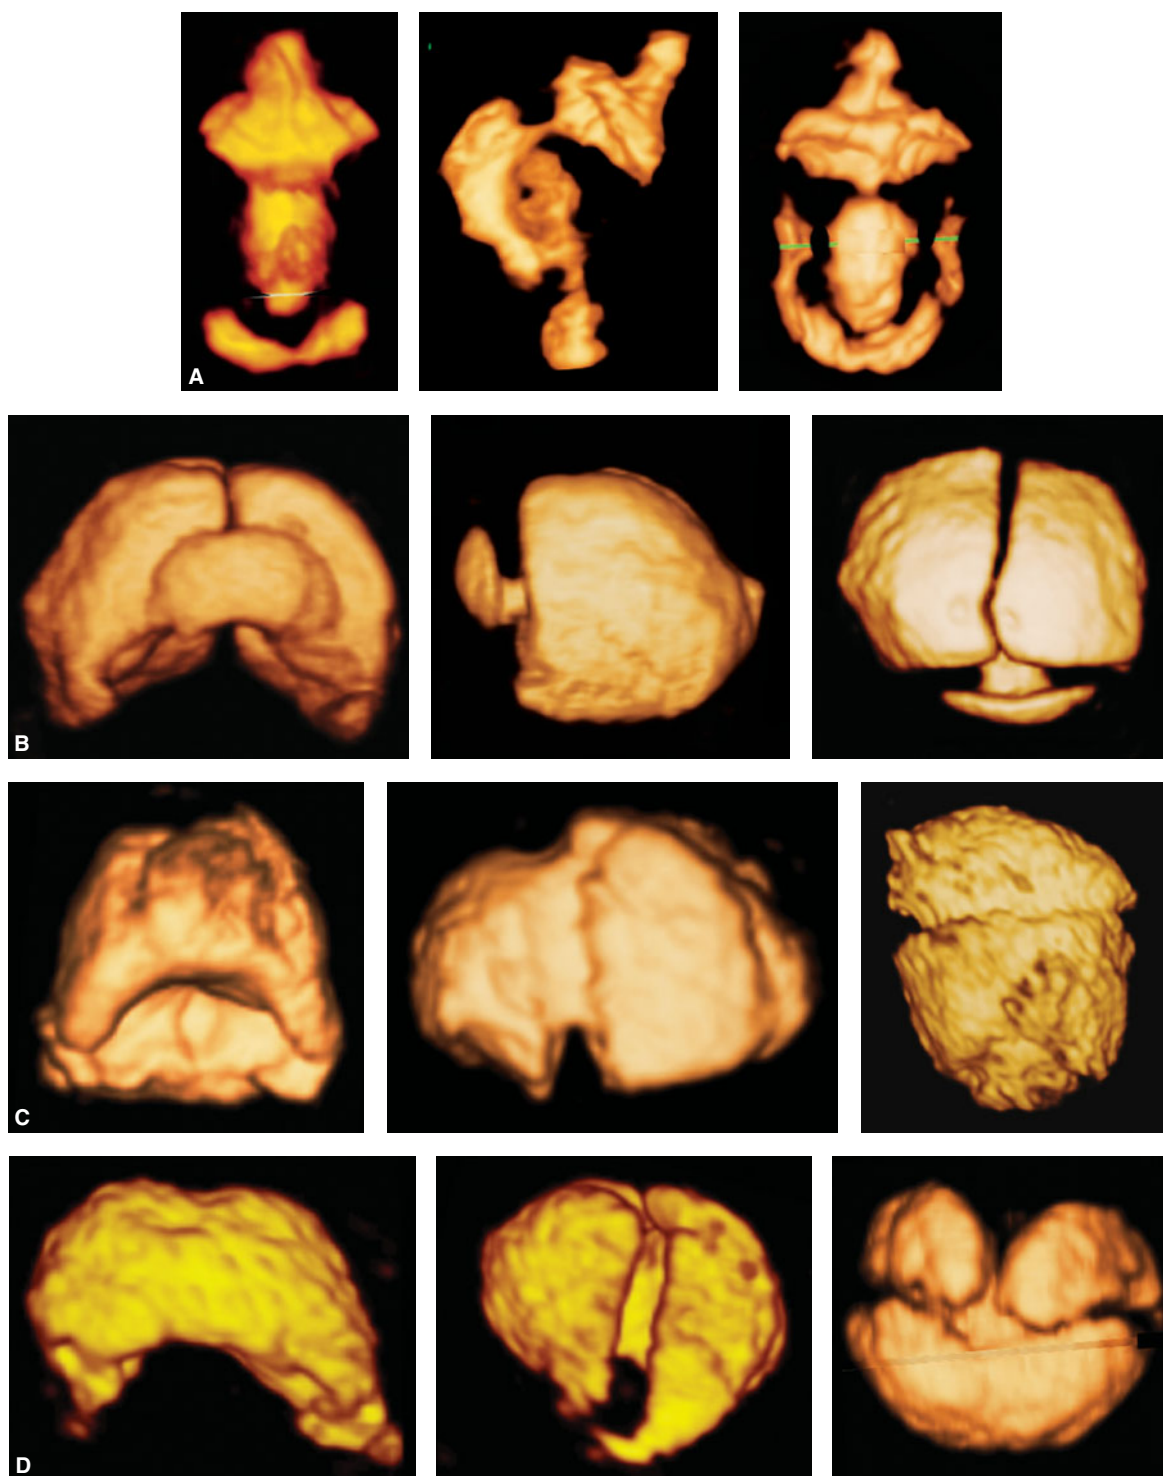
Pictorial table showing three-dimensional inversion rendering of the fluid in the ventricles of fetuses with holoprosencephaly in lateral, frontal, and superior views. (A) 9 weeks 2 days; (B) 10 weeks 2 days; (C) 13 weeks 5 days; (D) 14 weeks 5 days. (Reproduced, with permission, from Timor-Tritsch IE, Monteagudo A, Santos R. Three dimensional inversion rendering in the first and early second trimester fetal brain: Its use in holoprosencephaly. *Ultrasound Obstet Gynecol.* 2008;32:744–750.)
